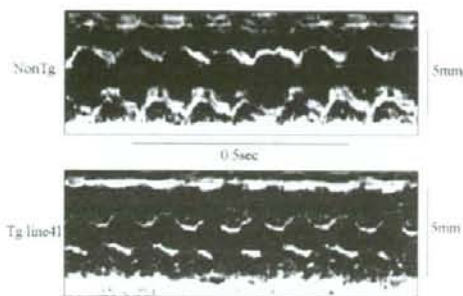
Echocardiographic analysis
